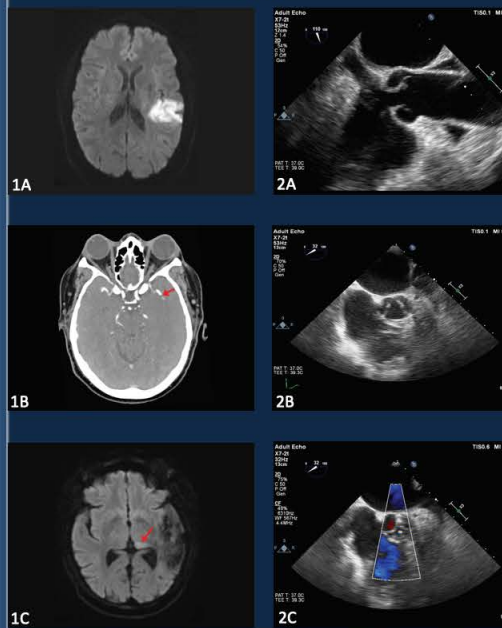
A) MRI brain showing subacute infarct in a left MCA distribution. B) CTA head showing occluded left inferior M2 MCA. C) MRI brain showing subacute infarct in the left ventral thalamus. Figure 2. A) TEE images.
